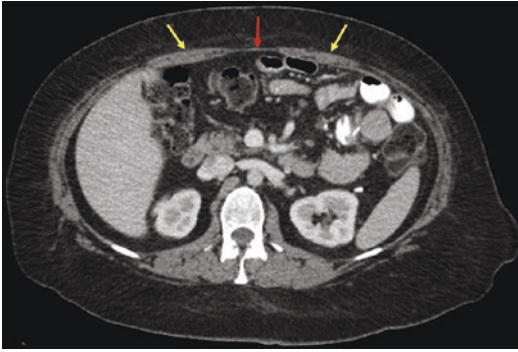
CT abdomen in a patient with ventral hernia and concomitant rectus diastasis. This axial cut shows the thinned rectus abdominis muscle bellies (yellow arrows) and a widened linea alba between them (red arrow)
